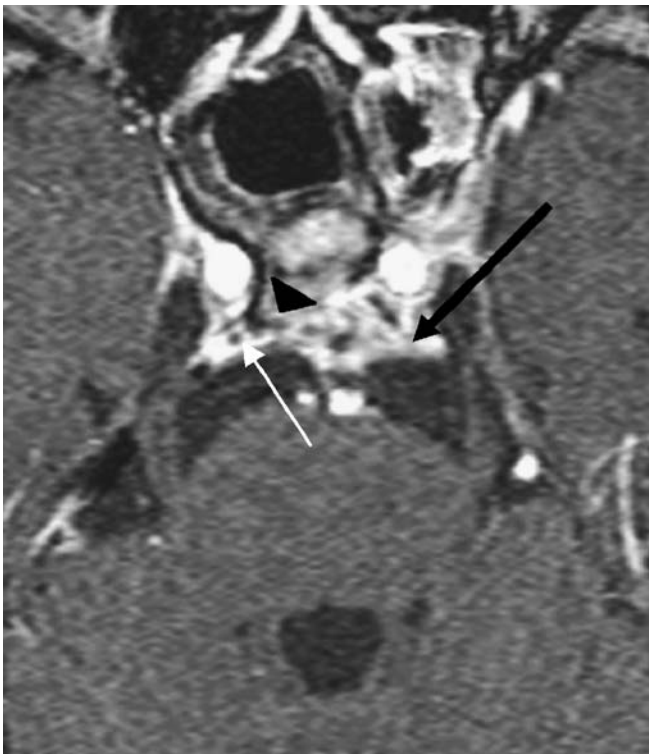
Invasive fungal infection of the sphenoid sinus affecting CN VI. a Axial T1W gadolinium-enhanced MR image shows enhancing soft tissue replacing the fatty marrow of the clivus and body of the sphenoid with destruction of the posterior cortical margin (black arrowhead). This abnormal soft tissue extends posteriorly into the pre-pontine cistern involving the basilar plexus and left VIth nerve (black arrow). Note the normal, non-enhancing, contralateral nerve, seen as a grey dot within the bright enhancing plexus (white arrow)
